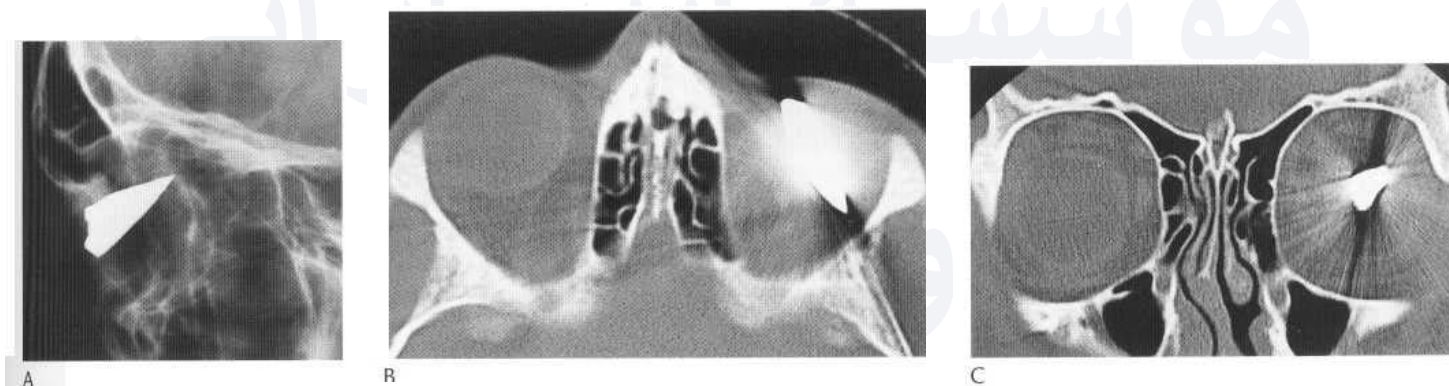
Intraorbital metallic foreign body. Fractured tip of knife blade demonstrated on lateral plain film (A) is well localised to left intraconal compartment by axial (B) and coronal (C) CT images. Retro-orbital haematoma obliterates the normal intraconal fat. There is rupture of the globe. (Case courtesy of Orlando Ortiz, M.D.)
